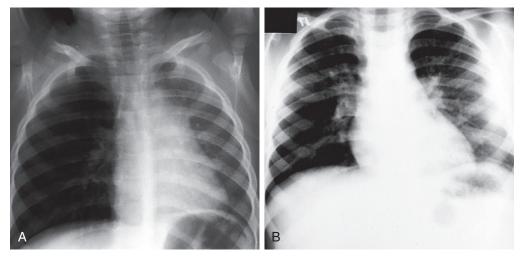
Foreign body aspiration, inspiratory and expiratory radiographs. A, This inspiratory film taken during fluoroscopy suggests hyperinflation of the right lower and middle lobes. B, This becomes much more evident on exhalation, when the hyperinflation persists and the mediastinum shifts to the opposite side. (*Courtesy Robert Gochman*, *MD*, *Schneider Children's Hospital*, Long Island Jewish Medical Center, New Hyde Park, N.Y.)
